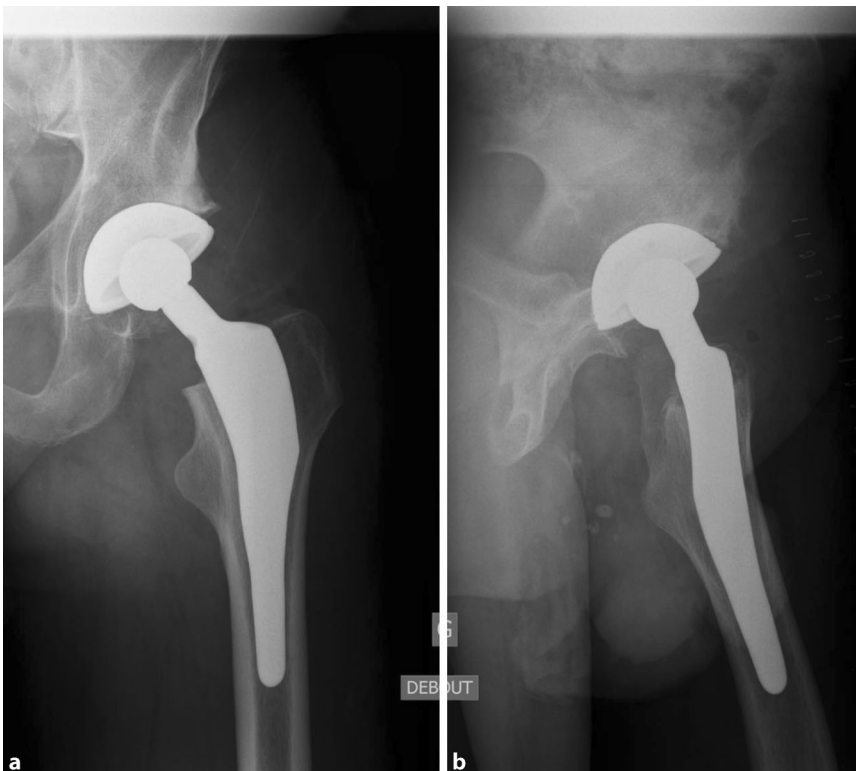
▲ Postoperative X-rays of a 44-year-old patient with custom-made cementless femoral stem. Postoperative X-ray images in frontal (a) and dorsal (b) views of a 44-year-old patient with a custom-made cementless femoral stem
